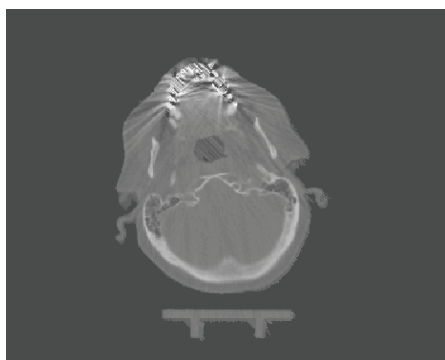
CT image after MR-based correction
